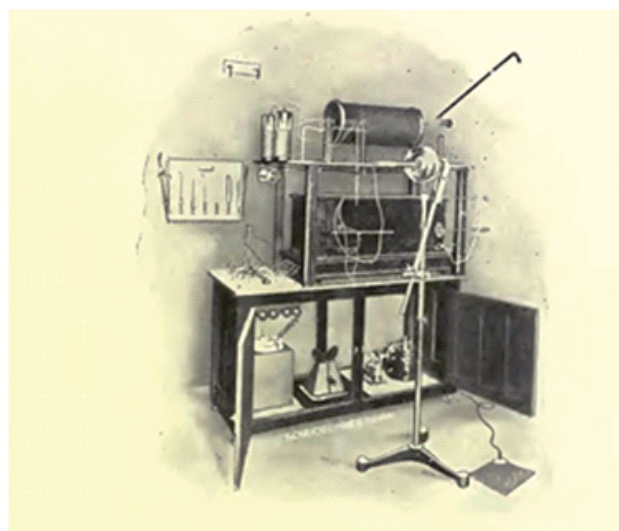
X-rays equipment used for the treatment of ocular cancer at early 20th century.
